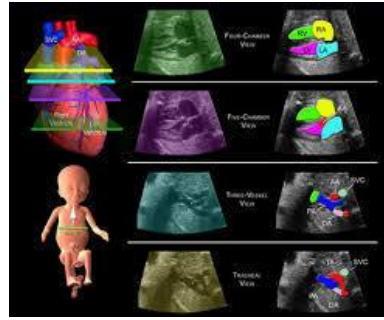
Model of Fetal Echocardiogram
